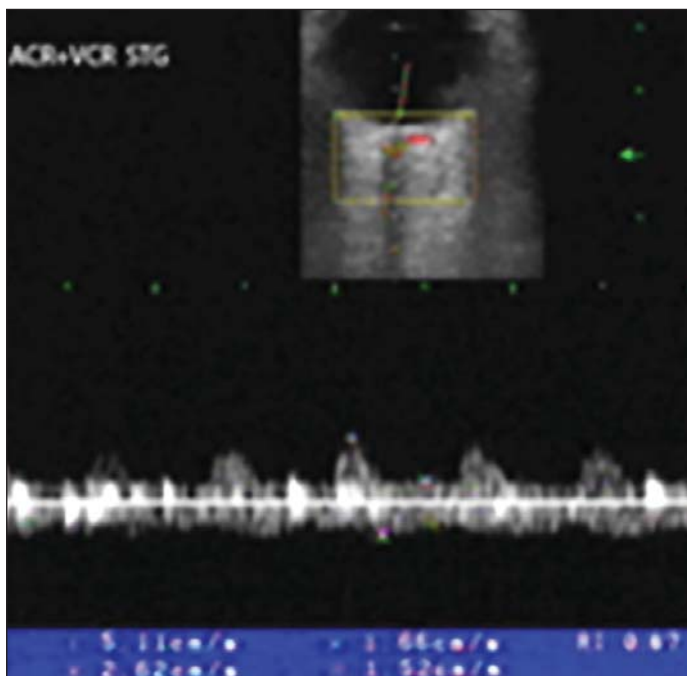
a. Patient MM-Spectral Doppler analysis of central retinal arteries (CRA).
